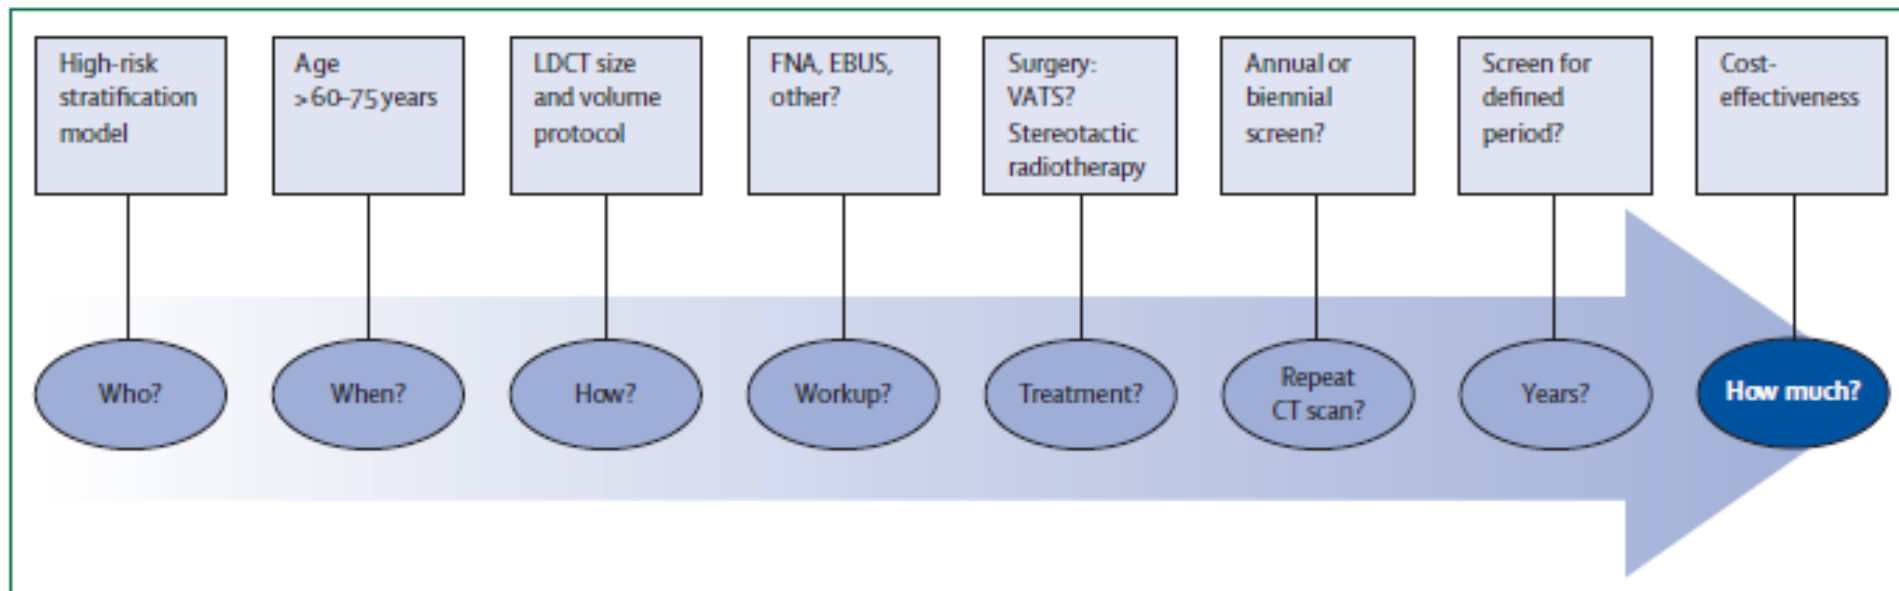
Decisions for implementation of CT screening
